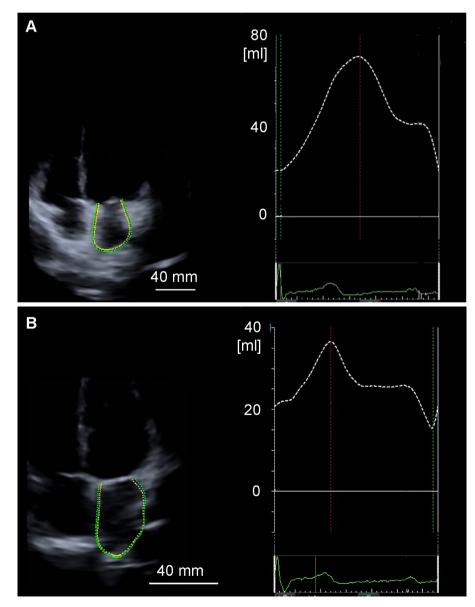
Representative image of three-dimensional speckle tracking echocardiography and time-left atrial volume curve during one cardiac cycle. (A) Well-controlled hypertension. (B) Normotensive subject. yellow line, endocardium of left atrium; black line, myocardium of left atrium; green line, epicardium of left atrium; broken line, time-left atrial volume curve.
